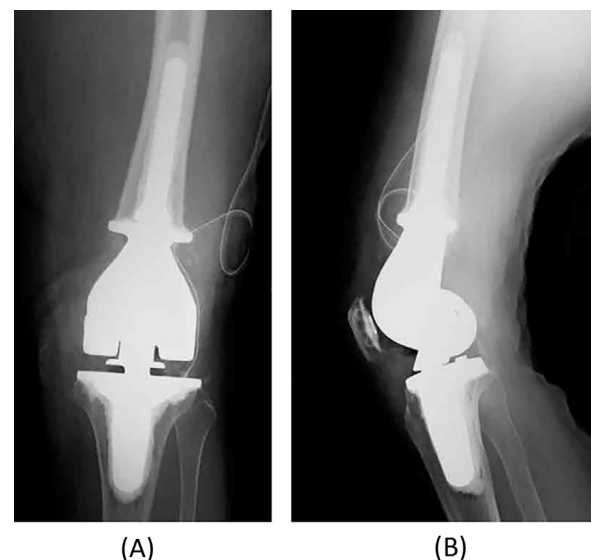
(A) Postoperative frontal and (B) lateral radiographs of the knee.
